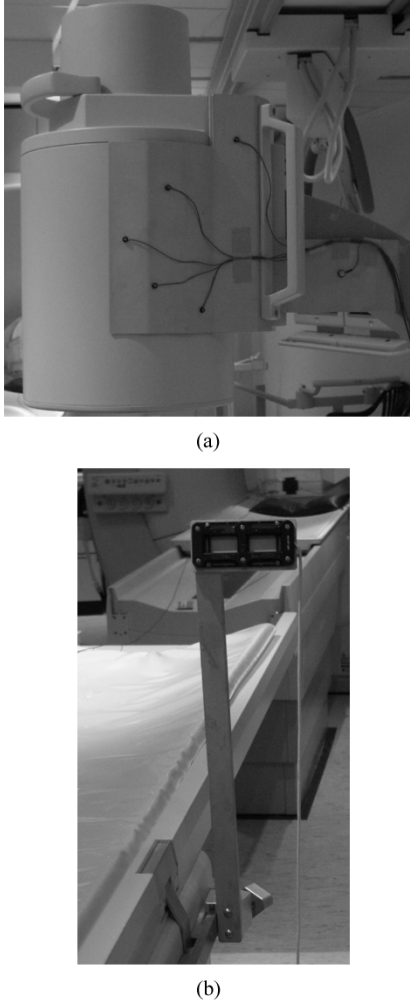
X-ray c-arm tracker (a) and X-ray table tracker (b).
